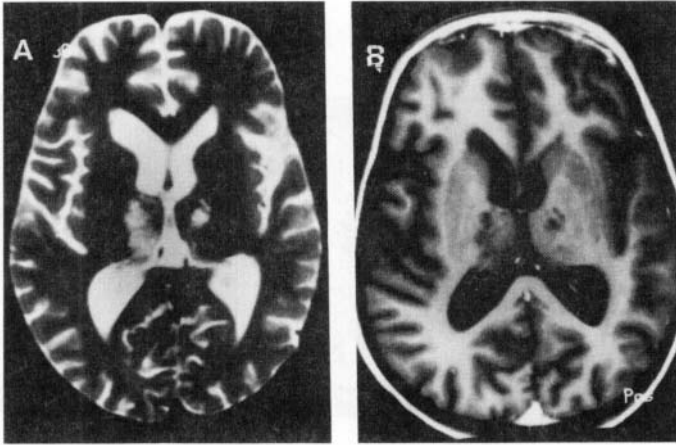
Japanese B encephalitis. Follow-up T2 image (a) in a case of JE shows evidence of hyperintense lesions in the medial part of bilateral thalami that appear hypointense on T1-weighted image (b).
